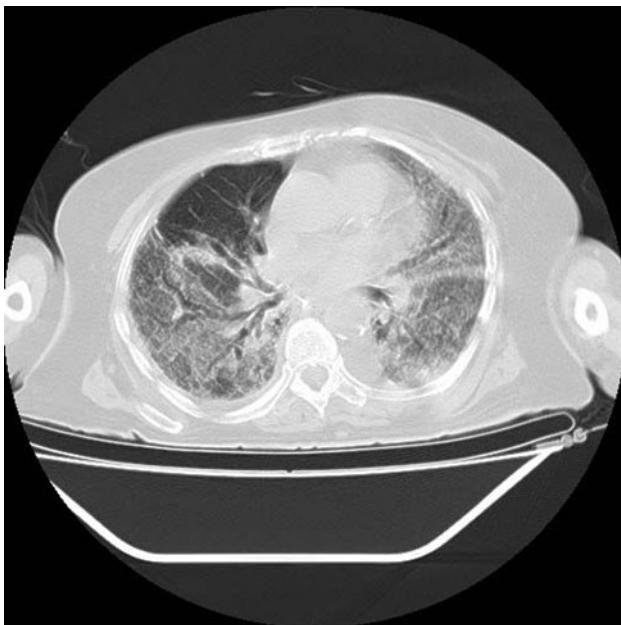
Lung computed tomography (CT) shows diffuse reticulonodular interstitial lesion suggesting severe interstitial pneumonia
